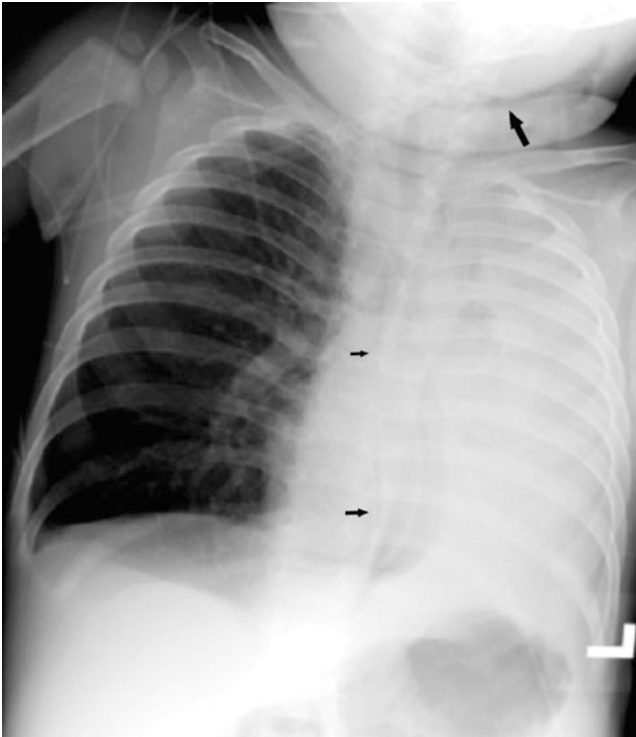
Young child with cast bronchitis. Initial chest radiograph reveals collapse of the left lung. There is subcutaneous air in the left aspect of the neck (*large arrow*) consistent with a pneumomediastinum (*small arrows*). There is compensatory overinflation of the right lung; the mediastinum is shifted to the left
